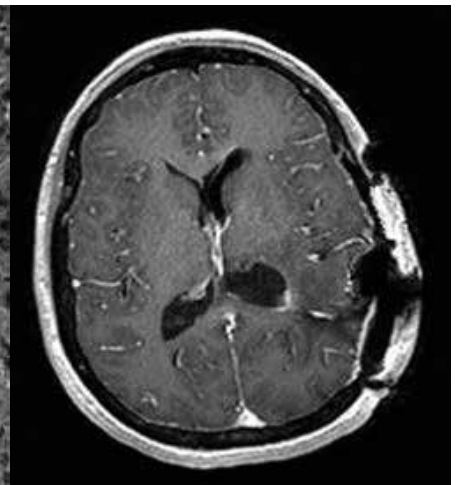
Postoperative CT image with contrast, 6 months after operation
